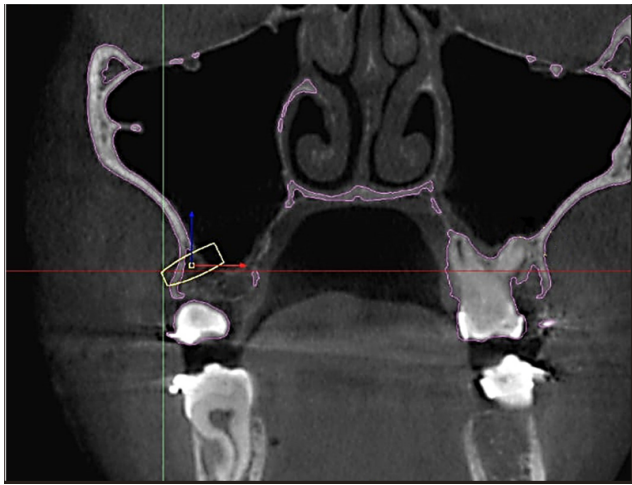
Axial CBCT planning for placement of implant.
